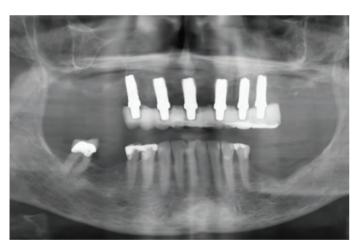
X-ray to verify implant placement position
